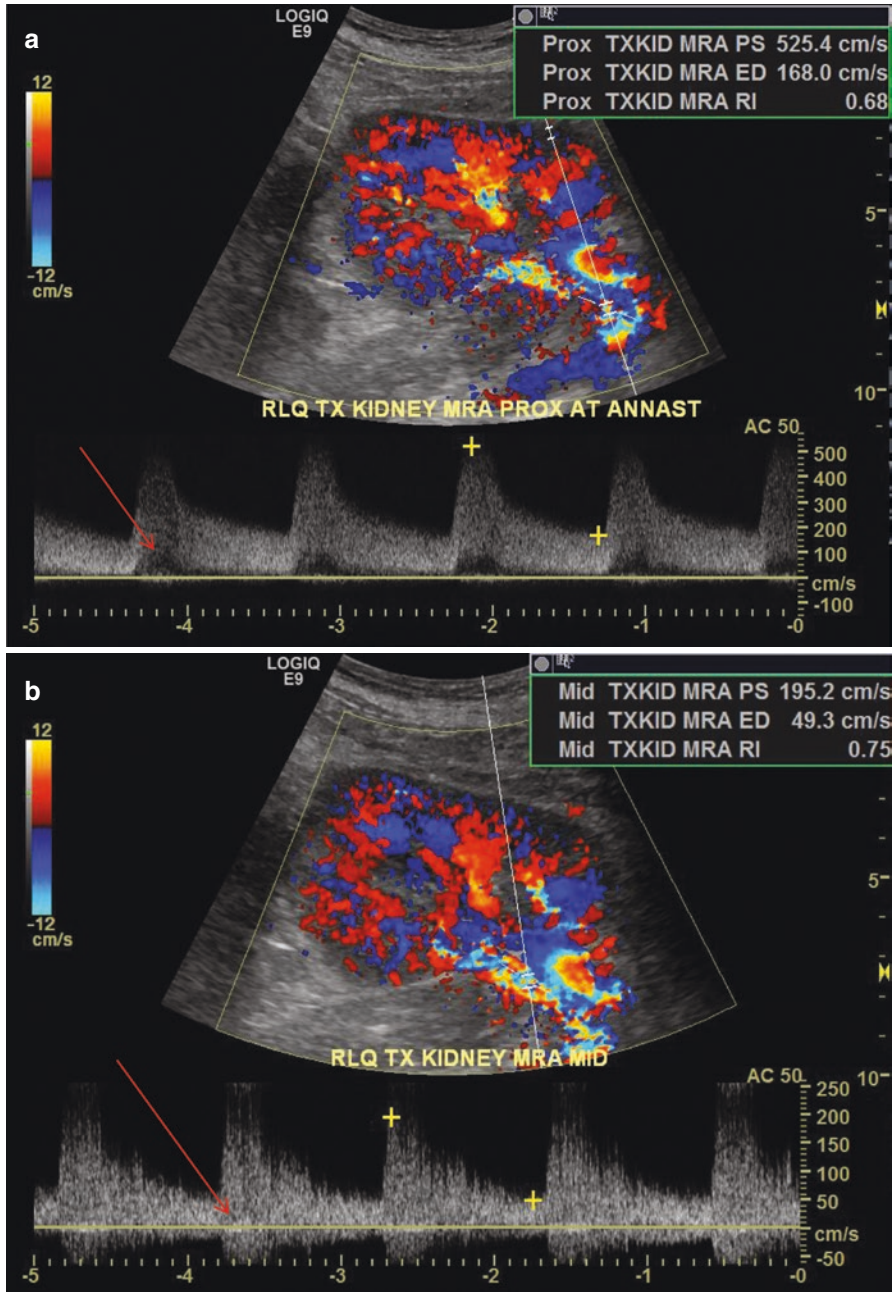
(a) Spectral Doppler US shows spectral narrowing of the waveforms in the proximal main renal artery at the anastomosis, indicative of increased laminar flow through an arterial stenosis. (b) Spectral Doppler US shows spectral broadening of the waveforms in the mid-main renal artery, indicative of increased turbulent flow distal to the arterial stenosis
